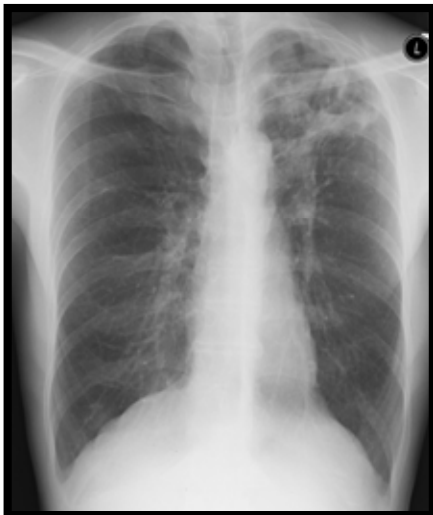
Chest radiograph showing a cavity in the left upper lobe in a patient with positive sputum smears with a cultured *M. malmoense* in a patient suffering COPD. (source: Hospital Drachten, the Netherlands. With permission).
